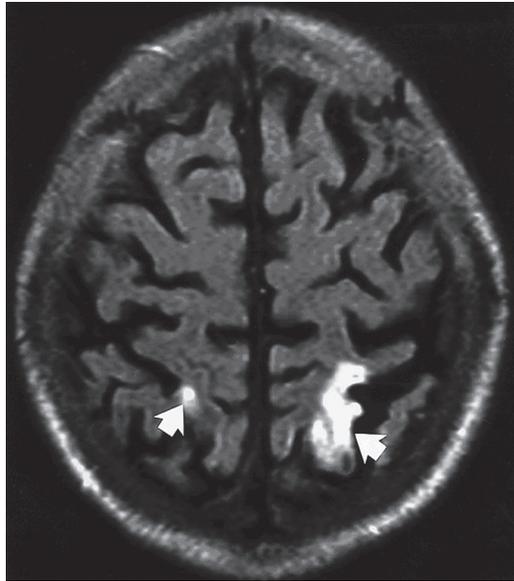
Transverse MR image before carotid angioplasty and stenting (FLAIR image, TR 6500, TE 120 ms, inversion delay 2000 ms)
